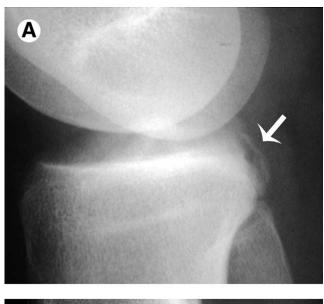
(A, B) Two examples of PCL avulsions (arrows), which are seen on lateral radiographs. The fragment may be quite thin as in (A). Displacement and rotation should be reported.
